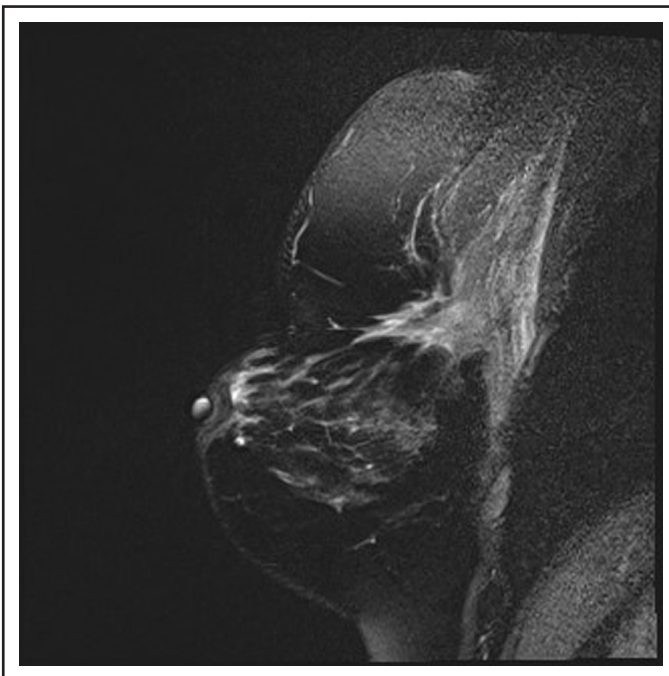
Pre-gadolinium (gadovist) T1-weighted surgical scar on the left breast.
